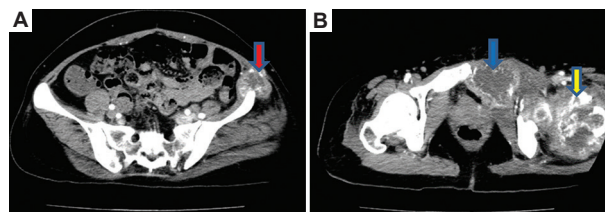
Abdominal computed tomography scans showing secondary pelvic and femoral bone lesions. (A) The lesion in the left pelvic bone (red arrow). (B) The lesion in the left pubis (blue arrow) and left femur bone (yellow arrow).
